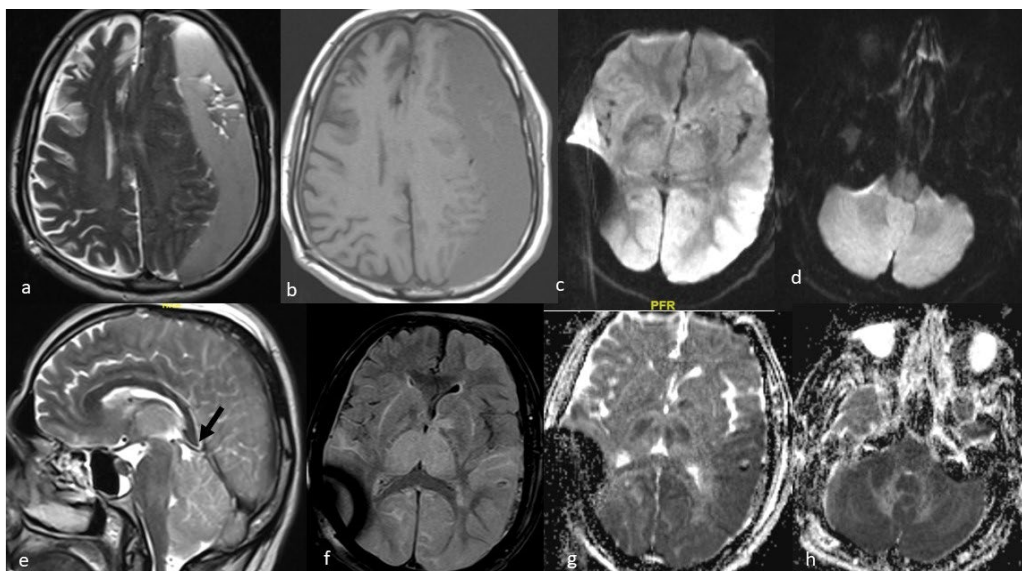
T2W and T1W MRI image (a&b) showing large chronic left frontoparietal subdural hematoma. Post-operative DWI MRI (c,d,g&h) showing large areas of diffusion restriction involving bilateral parieto-occipital regions, cerebellum, thalamus and brain stem, suggesting irreversible damage. Post-operative sagittal T2W MRI image (e) showing distorted and pointed splenium (black arrow) compressing the vein of Galen. Flair MRI image (f) showing signal change and swelling in bilateral thalamus.
